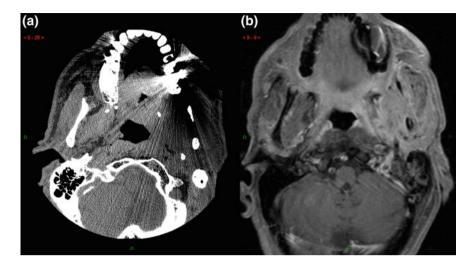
a Non-contrast CT. b Axial T1 post contrast. Patient with a history of recurrent tumor outside of radiation field. On CT, the lesion is obscured by dental artifact. On MRI, the infiltrative nature of the tumor recurrence is clearly seen within the masticator space
